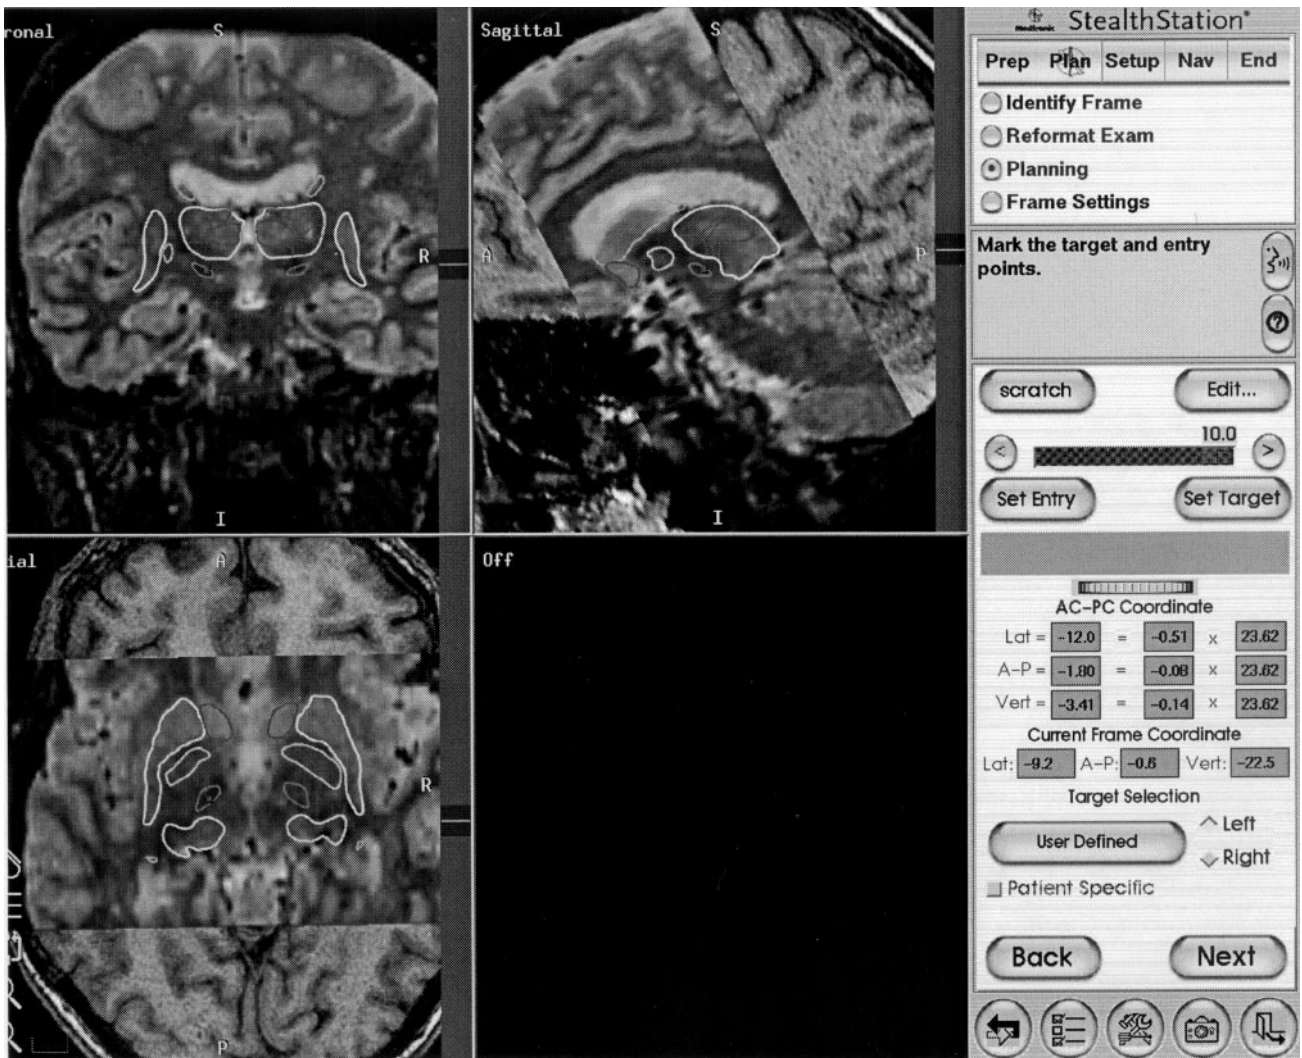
Patient-specific atlas. StealthStation display showing two independent MRI datasets (T1-weighted and T2) coregistered to each other. Superimposed upon these gray scale images is a color atlas of the deep cerebral nuclei. The atlas from which the contours of these nuclei have been obtained has been elastically deformed to match the anatomy of the patient. Note the close correspondence between the atlas and the underlying structural anatomy. Image courtesy of Dr. Jaimie Henderson, Division of Neurosurgery, Saint Louis University School of Medicine.
